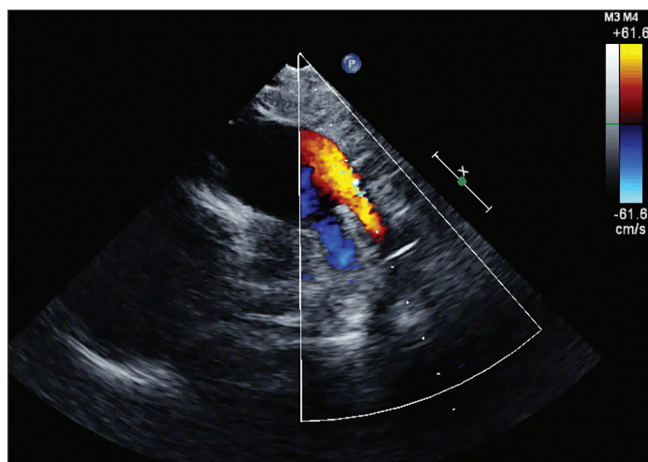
Color Doppler echocardiogram shows laminar left to right flows across a large patent ductus arteriosus in parasternal short axis view [Movie 1]
